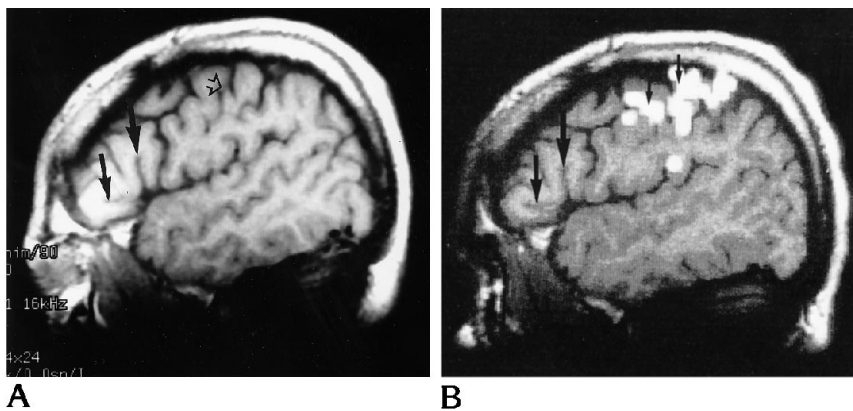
Parasagittal MR image (A) and corresponding functional image of the finger movement task (B) in a healthy volunteer. Note the anterior ascending and anterior horizontal rami (arrows) used as landmarks for the inferior frontal gyrus. The activation in the sensorimotor cortex (vertical arrows in B) corresponds with the central sulcus (open arrow in A) selected on the basis of anatomic landmarks.
